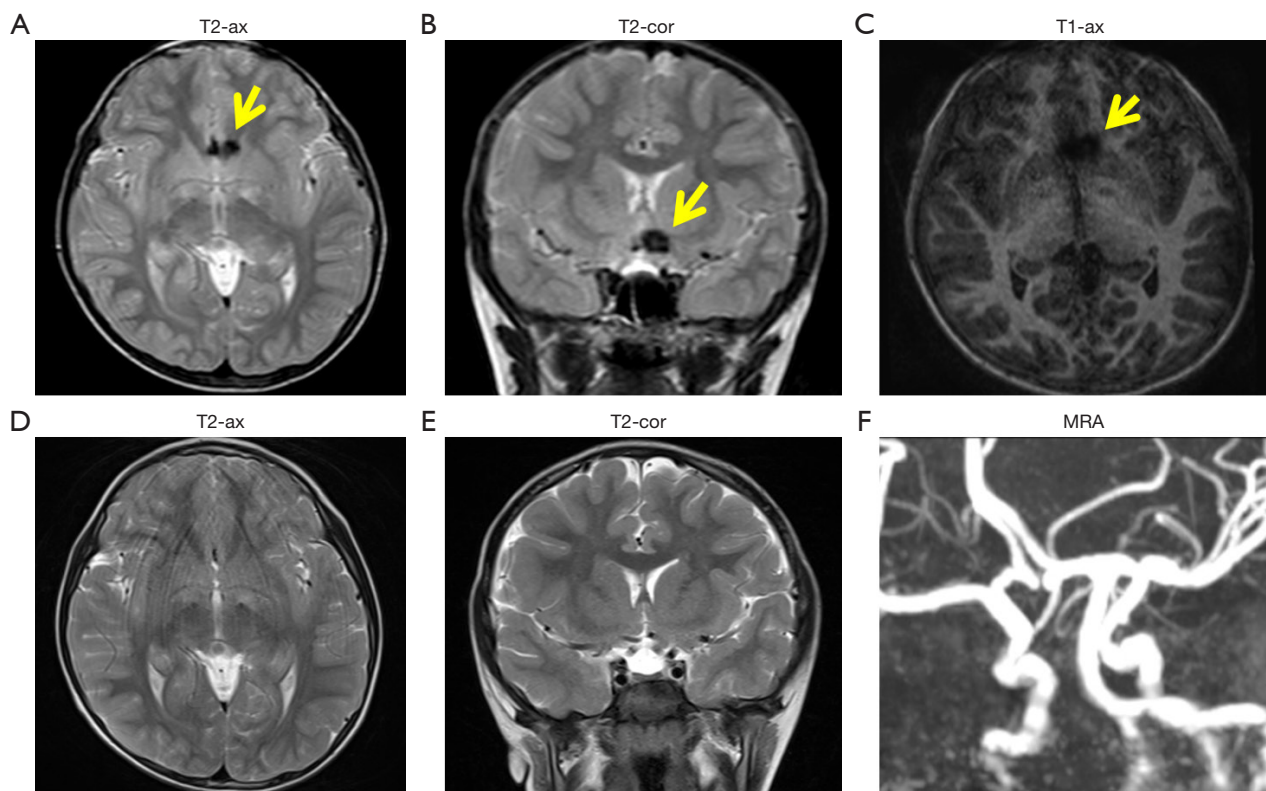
Aneurysm-mimicking artifact at ACoA region on axial and coronal conventional MRI is shown (yellow arrows, A-C). Second MRI and TOF angiography shows no evidence of aneurysm (D-F). ACoA, anterior communicating artery; MRI, magnetic resonance imaging; TOF, time-of-flight; ax, axial; cor, coronal; MRA, magnetic resonance angiography.
